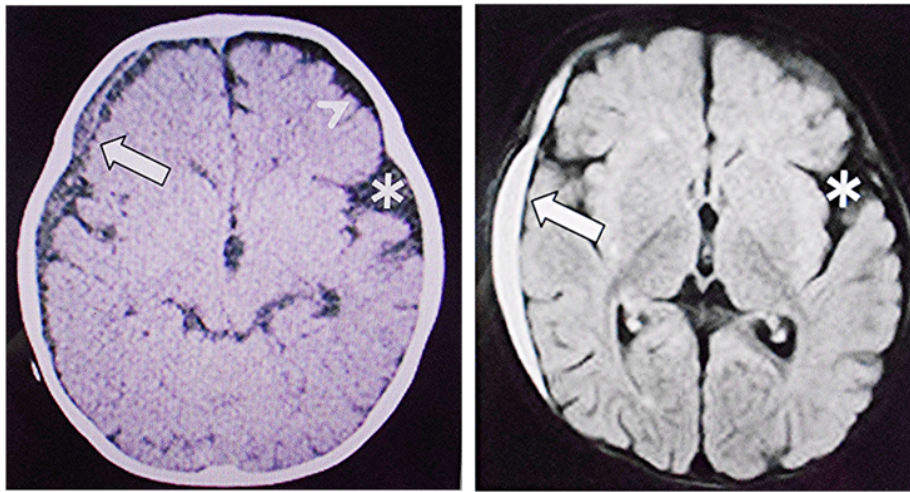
Case 3 (No. 12), male aged 9 months. Left: Axial CT on arrival showing a mixed-density subdural hematoma on the right side (arrow) with no mass effect. Note enlargement of subarachnoid space (arrowhead) and the LSF on the left side. (asterisk). Right: Fluid-attenuated inversion recovery MRI at day 2 after onset showing the SDH on the right side (arrow) and the LSF on the left side. (asterisk) No cerebral parenchymal abnormality was confirmed on the other MRI sequences (not shown).
